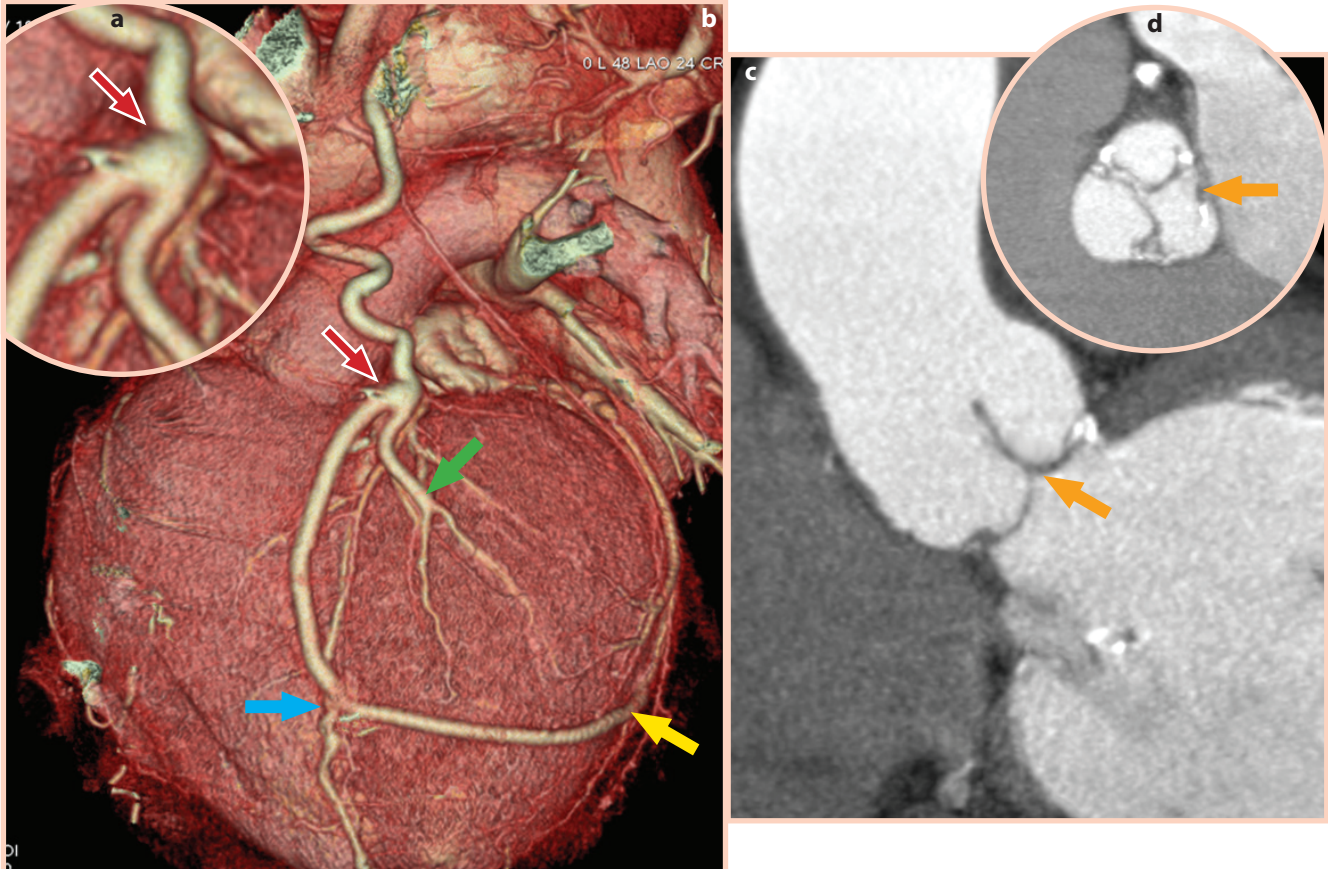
CT image of distal anastomosis on the left internal mammary artery (LIMA) with the first diagonal branch (b, green arrow) as well as proximal anastomosis with the left radial artery as a Y anastomosis on LIMA (a, b, red arrow) that continues as a “jump” anastomosis to LAD (b, blue arrow) and to the marginal branch (b, yellow arrow). The reconstructed aortic valve is shown (with three handcrafted pericardial leaflets) (c, d, orange arrow).
